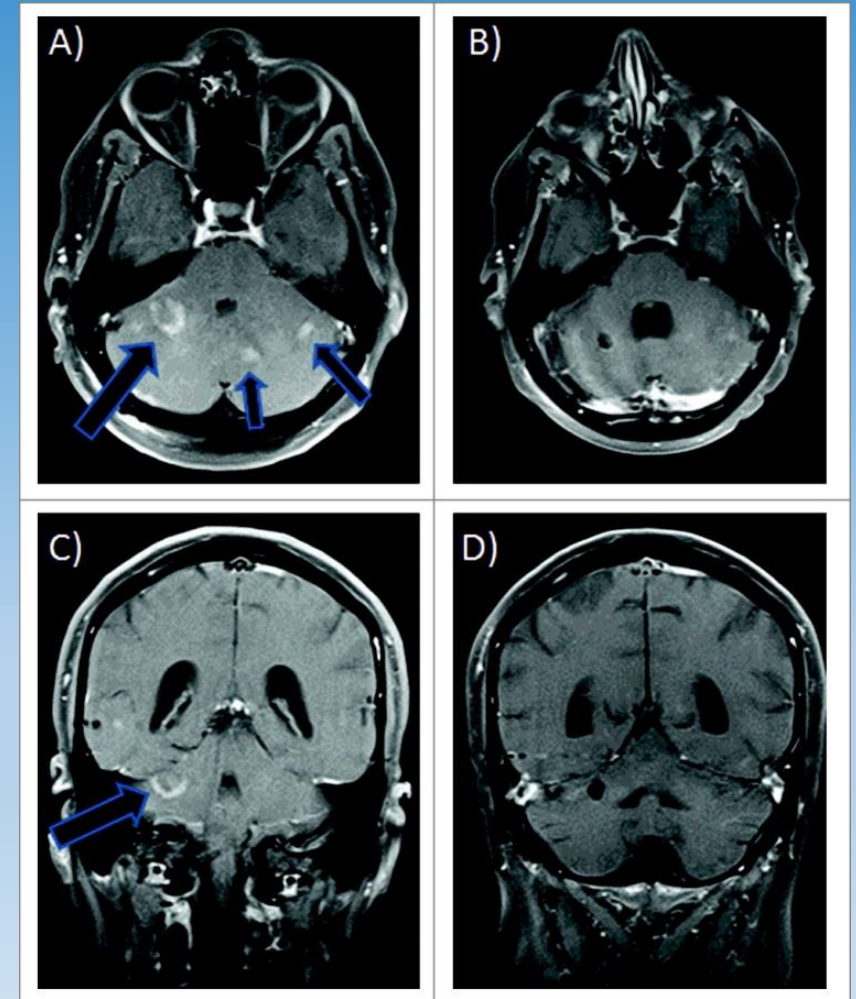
MRI images of unresectable multifocal medulloblastoma at time of diagnosis (A and C) and after four months of vismodegib therapy (B and D). Images are shown in axial sections with contrast (top) and coronal sections (bottom).
